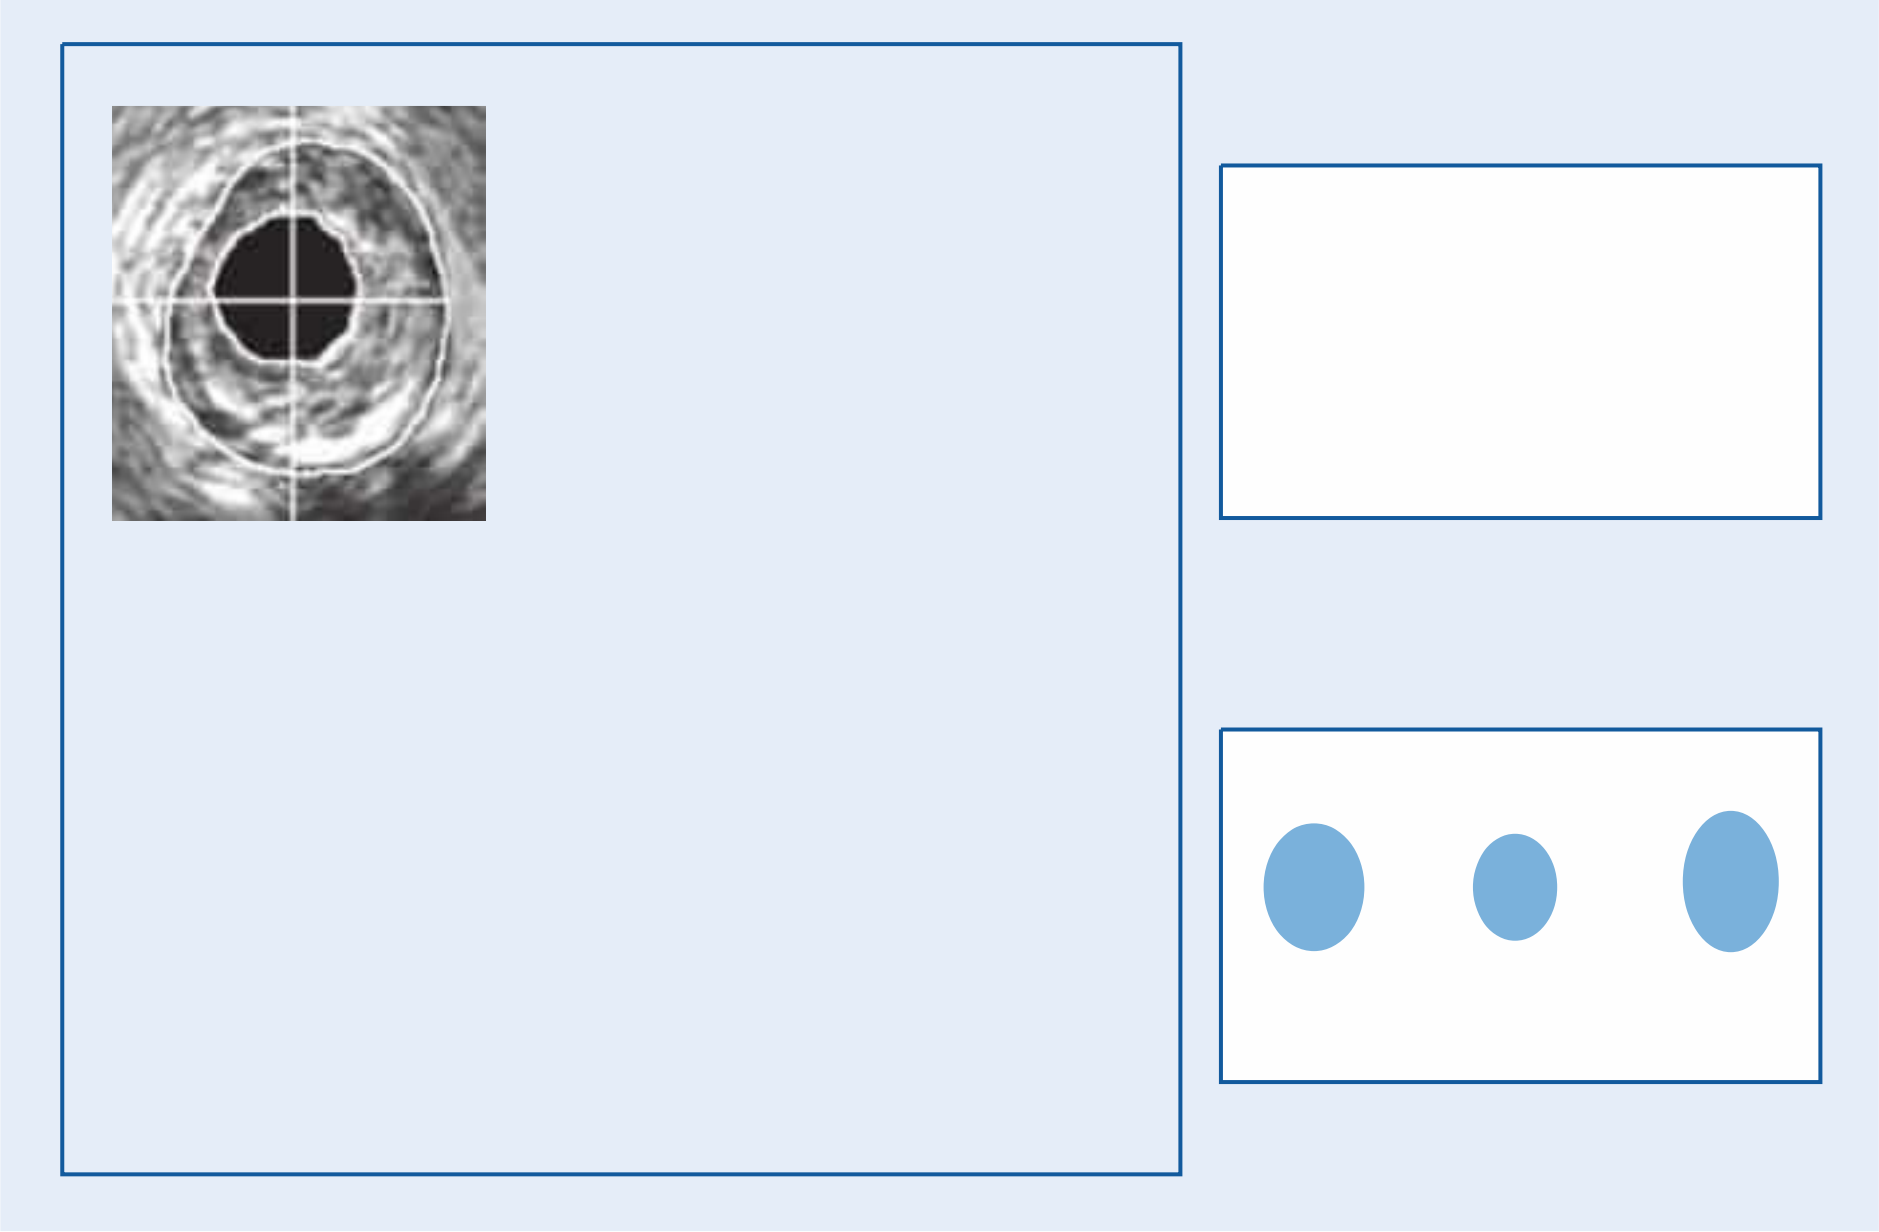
Plaque formation with negative remodeling demonstrated by intravascular ultrasound during distal-to-proximal catheter withdrawal. The largest vascular diameter is not found in the area of greatest luminal narrowing, as the vascular area in that segment is reduced compared with the proximal and distal segments. The smallest vessel diameter based on lumen–adventitia distance is found in the stenotic segment. Lesions with negative remodeling are less vulnerable to plaque rupture.¹⁰
